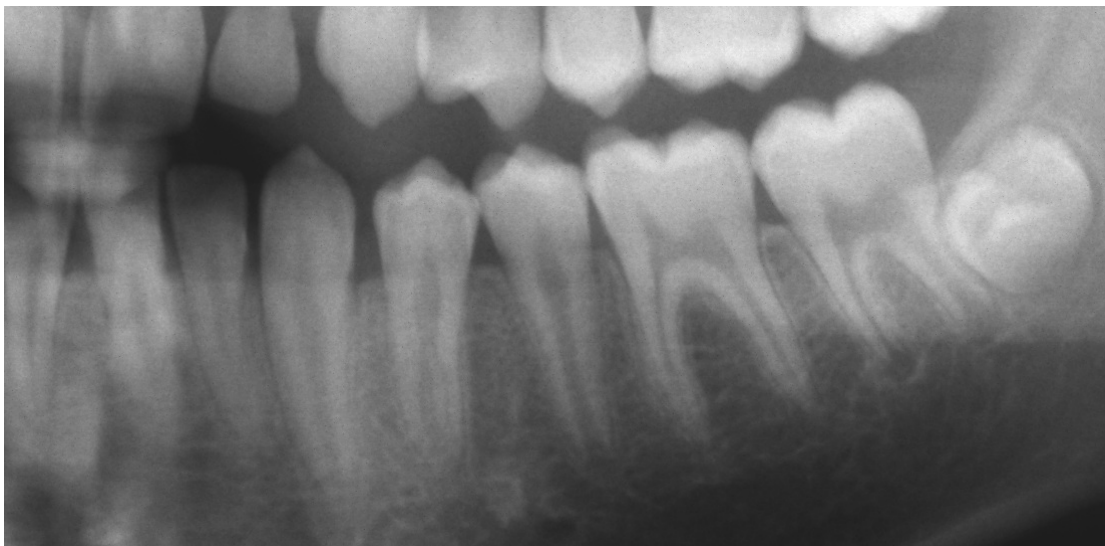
Another clinical example. A cropped panoramic radiograph of a 13.4-year-old boy. The formation stages of the seven left mandibular teeth are (from M2) G,H,G,G,G,H,H. The summed score gives him the dental age 13.2.
